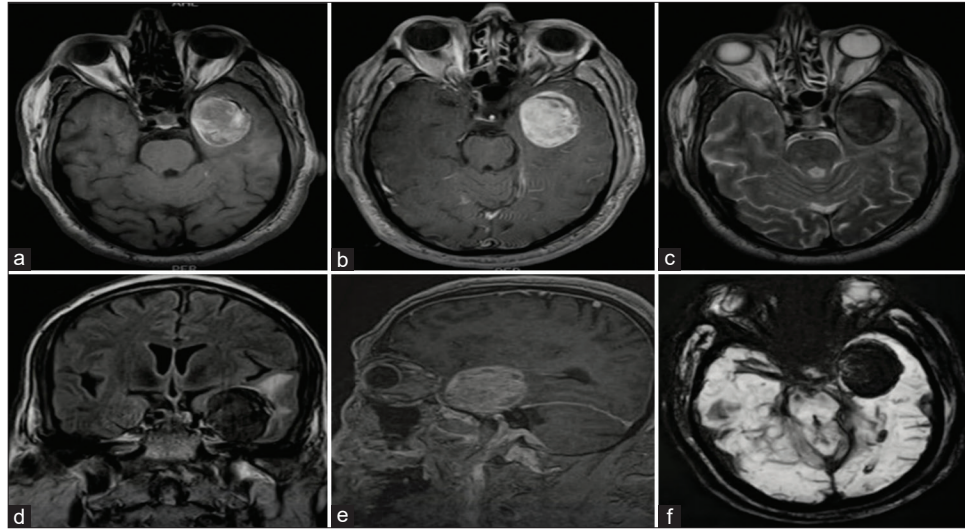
Preoperative multiplanar and multisequential MRI of the brain. (a) T1 without contrast shows a heterogeneous hyperintense lesion in the left temporal region, (b) T1 with contrast shows further enhancement on contrast administration, (c) T2 shows a hypointense lesion with surrounding hyperintense signals, (d) fluid-attenuated inversion recovery showing edema surrounding lesion, (e) T1 post contrast sagittal, and (f) susceptibility weighted image displaying areas of signal drop out.
